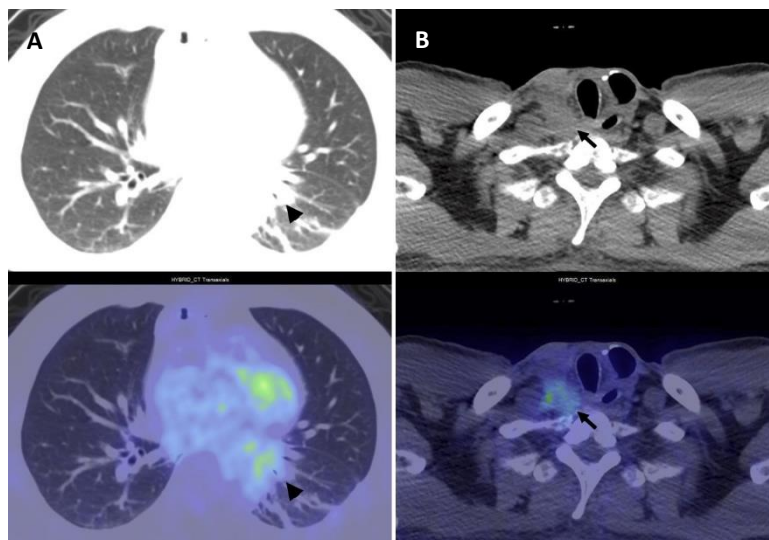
¹⁸F-FDG PET/CT fusion images demonstrate two distinct lesions: (A) A mildly ¹⁸F-FDG-avid lesion in the left lower lobe of the lung, infiltrating the left lower lobar bronchus with associated bronchial narrowing (arrowheads). (B) A hypermetabolic soft-tissue lesion in the right cervical region, adjacent to the upper trachea at the C7–T1 level, near the esophagogastric anastomosis (arrows)
